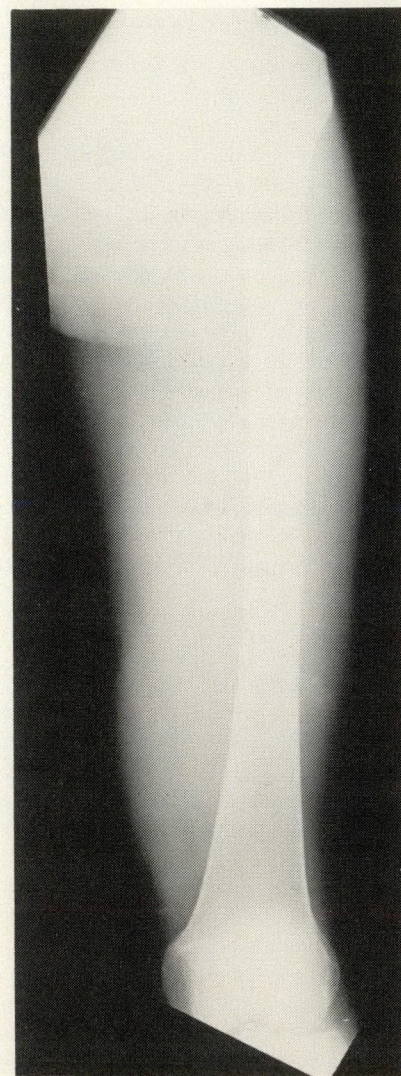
Plain x-ray film of thigh of 35-year-old woman, known to have neurofibromatosis. Ill-defined soft-tissue mass is present medially.
